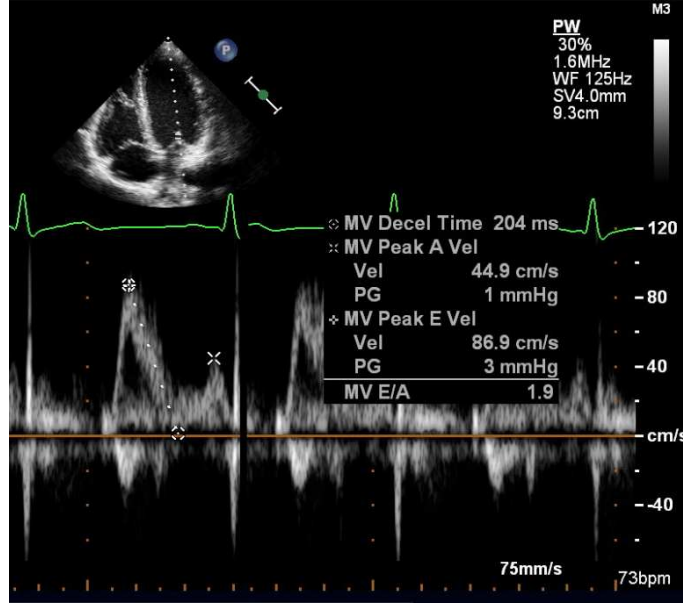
Analysis of flow through mitral valve using pulse Doppler measurement.
